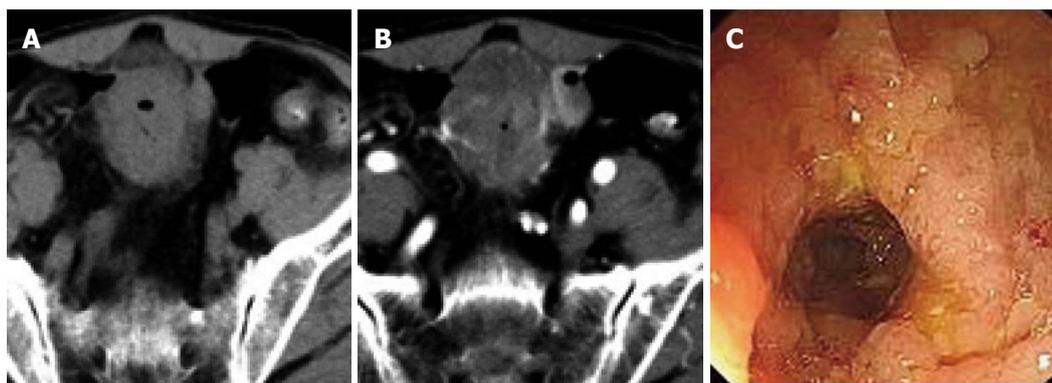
Computed tomography and endoscopic changes of primary small intestinal lymphoma in a 39-year-old man. A: Plain computed tomography (CT) scan showed bowel thickening in the distal ileum; B: During the arterial phase, contrast-enhanced CT scan demonstrated mild enhancement; C: Endoscopic examination showed a raised lesion in the ileum.
